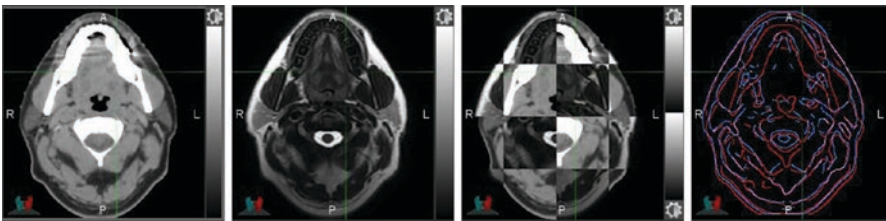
An axial slice of an example H&N patient from a planning CT and follow-up T2-weighted MRI scan. MRI provides better soft tissue contrast compared to CT. Visual inspection of the registration is performed using checkerboard display for image alignment. This process can be facilitated utilizing edges generated from CT and MRI as shown in *blue* and *red*, respectively
